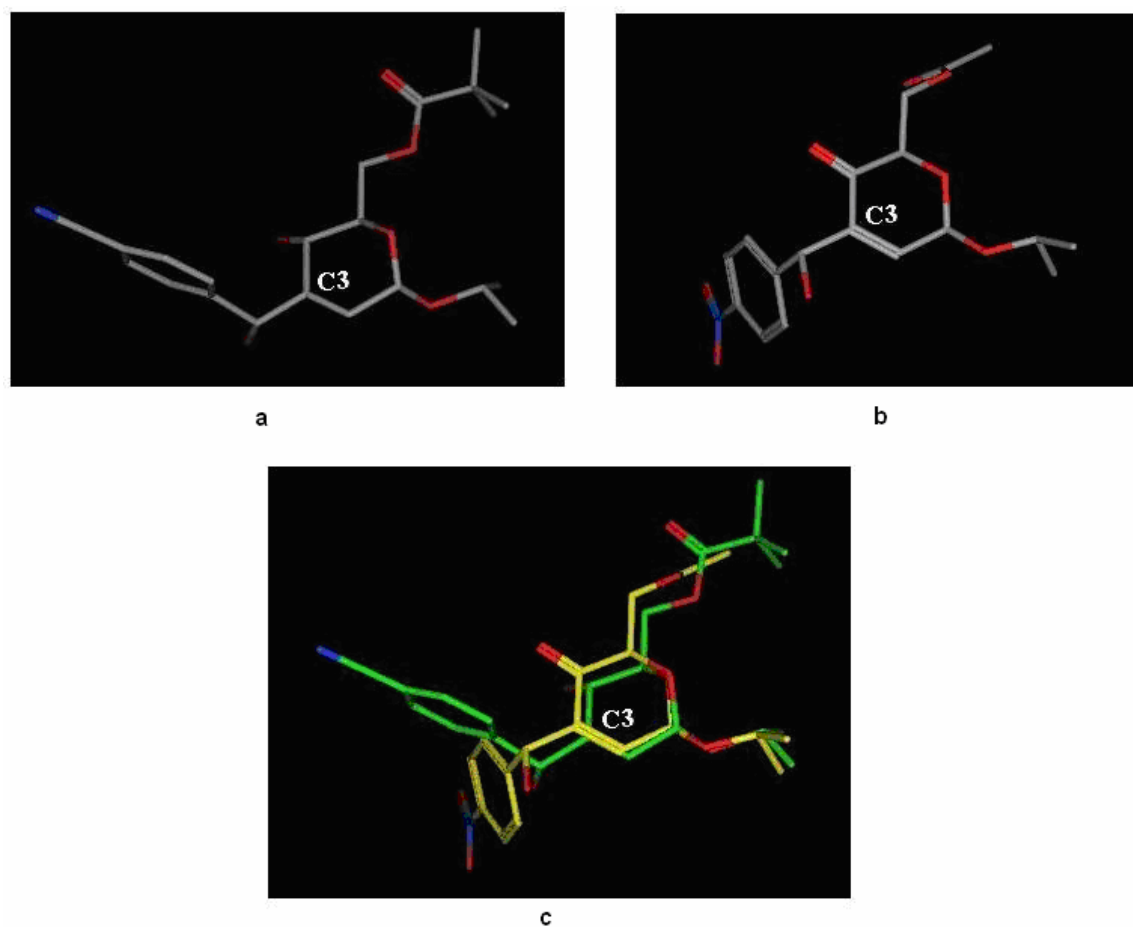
(a) X-ray structure of 4dr; (b) conformational analysis derived minimum energy structure of 5c; (c) superimposition pose of 4dr (carbons: green) and 5c (carbons: yellow); in all, oxygens are in red and nitrogens are in blue; hydrogens are suppressed for clarity.
